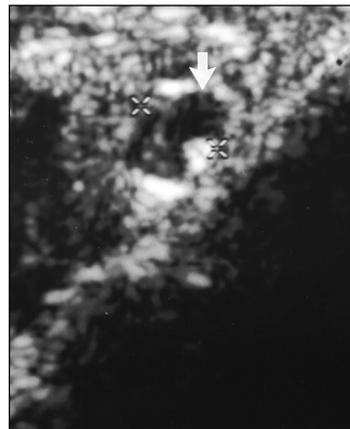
38-year-old man with schwannoma. Longitudinal 5-12-MHz sonogram shows cystic degeneration as anechoic spaces in schwannoma of radial nerve, biopsied under sonography guidance.
